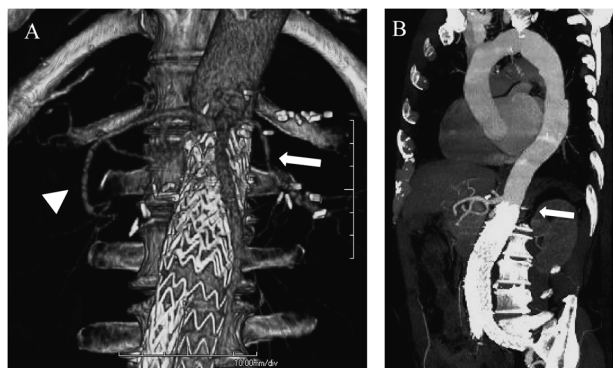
Postoperative contrast-enhanced computed tomography. (A) Three-dimensional volume-rendering reconstruction showing the patent bypass (white arrowhead: hepato-renal bypass; white arrow: spleno-renal bypass). (B) Multiplanar reconstruction showing the successful placement of the stent-graft below the superior mesenteric artery (white arrow).
